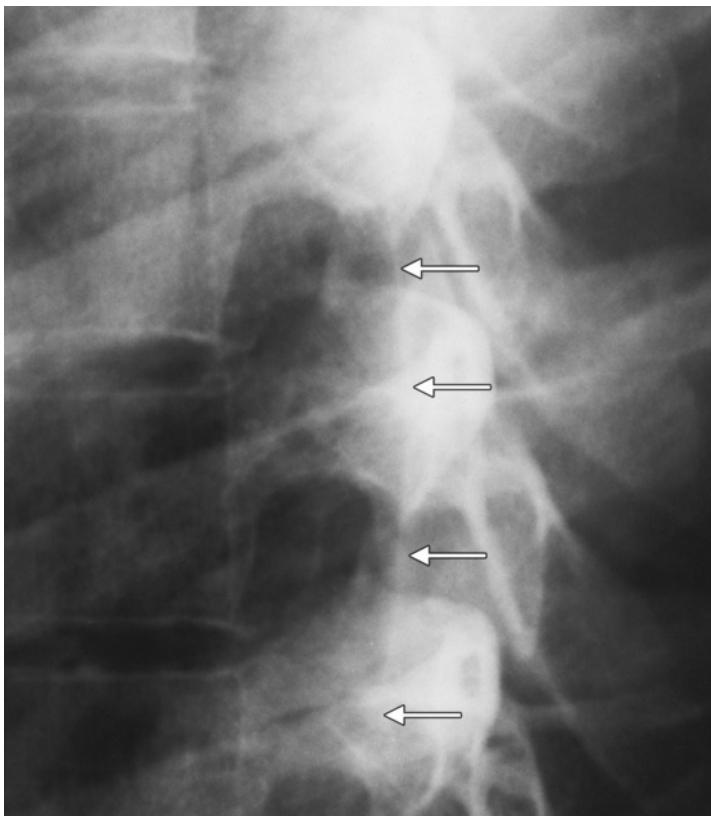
Tangentially imaged pleura (detail enlargement of the chest radiograph). The posterior margin of the lung is marked by the line of the pleura (white arrows) coursing between rib arches.
